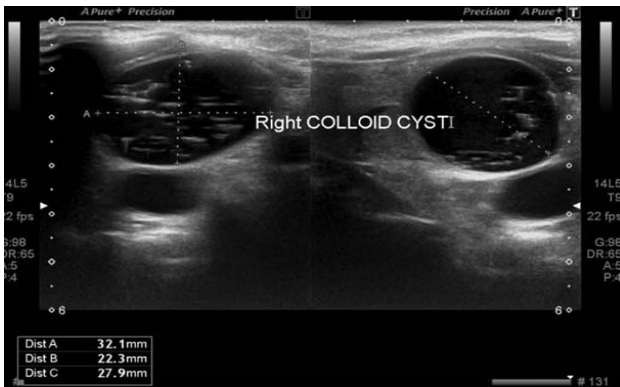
Grey scale ultrasound of thyroid gland showing a cyst in right lobe of thyroid gland with multiple comet tail artifact within the cyst representing thyroid colloid cyst.
